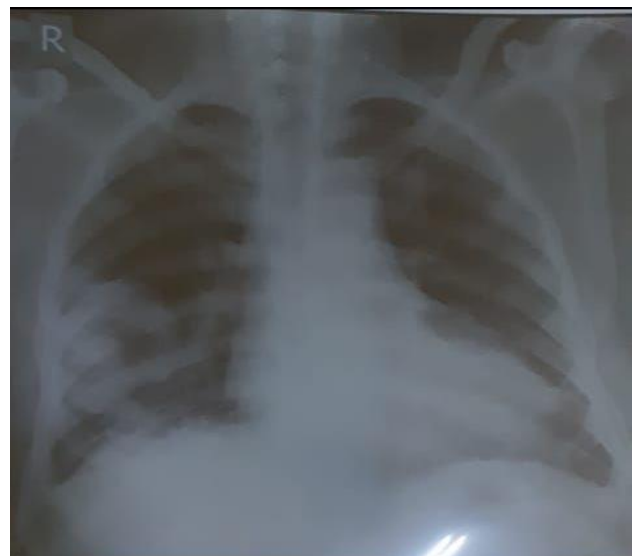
Chest X-ray showing right middle lobe cavitary lesion.
